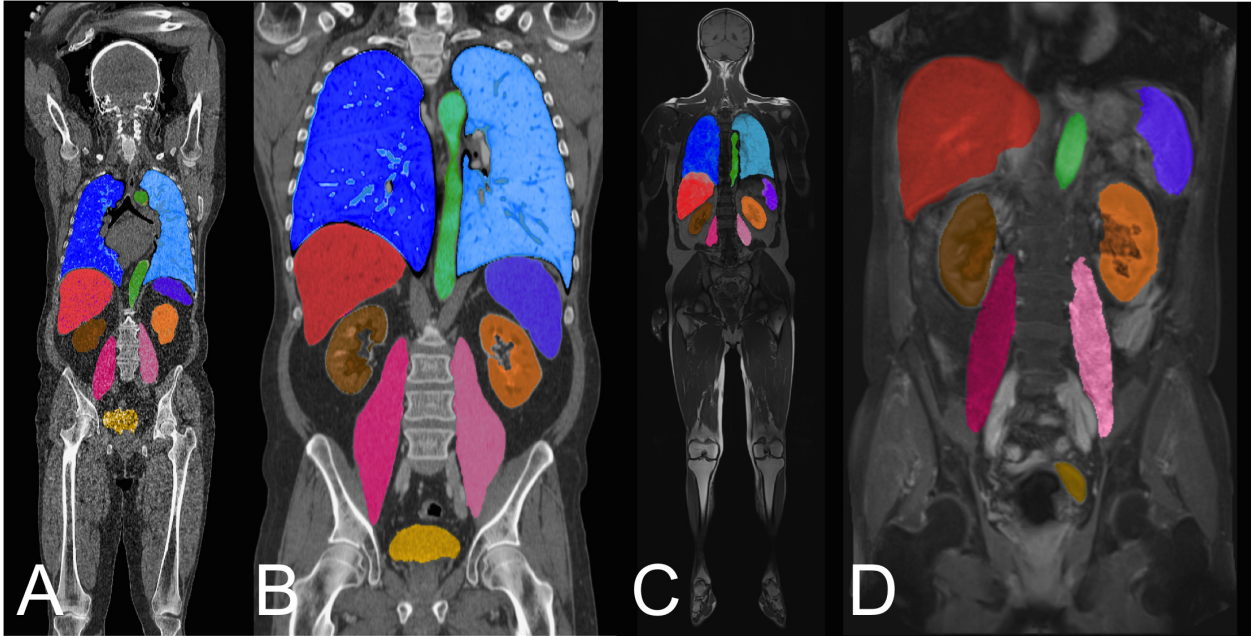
Sample data set volumes. A) Whole-body unenhanced CT; B) contrast-enhanced CT of the trunk; C) whole-body unenhanced MR; D) contrast-enhanced MR of the abdomen
